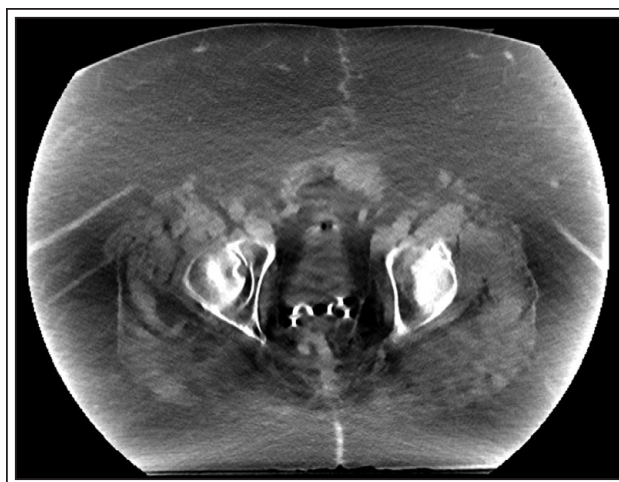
CT abdomen/pelvis after stent placement continues to demonstrate a small pear-shaped bladder surrounded with increased perivesical and perirectal fat consistent with pelvic lipomatosis.
